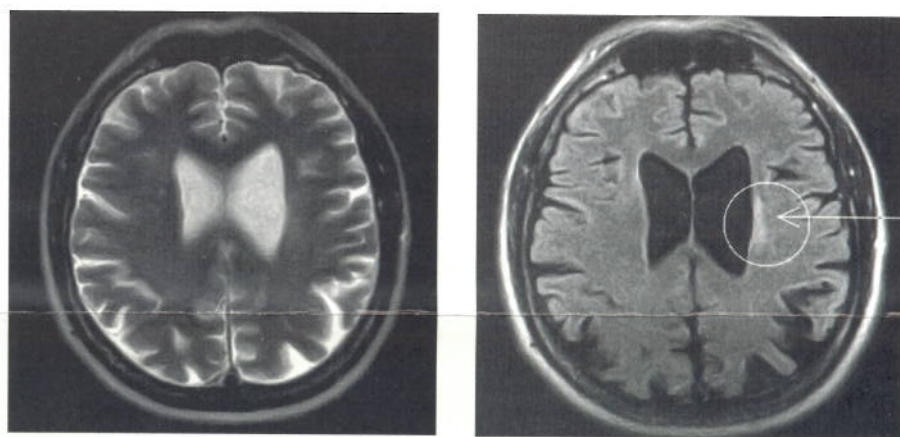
New Turbo FLAIR sequence for brains improves conspicuity of white matter disease. Siemens exclusive in open MRI!
